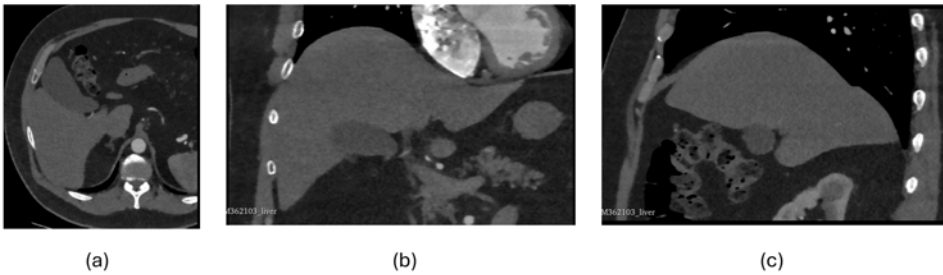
Liver CT scan: (a) axial slice, (b) coronal slice and (c) sagittal slice.
